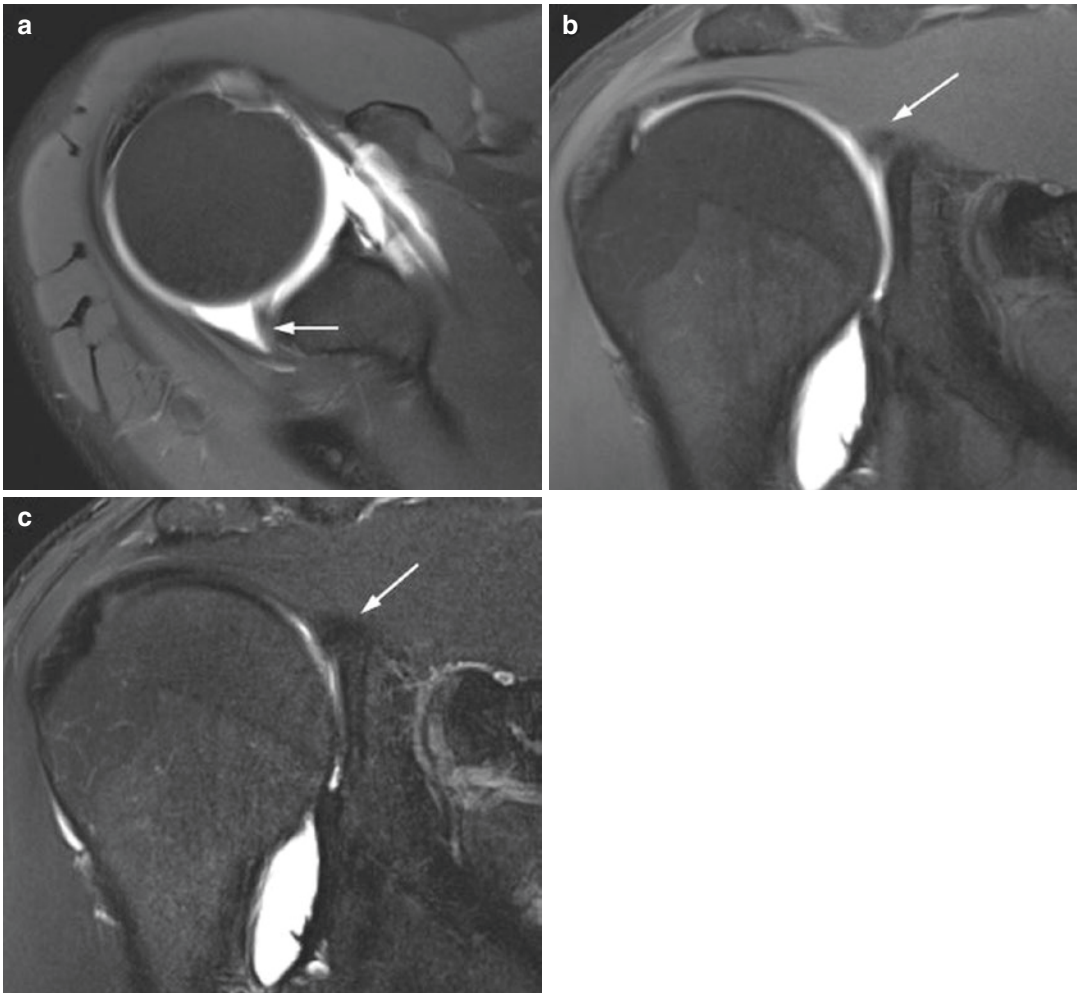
Magic angle phenomenon in the posterosuperior labrum. (a) Axial and (b) coronal fat-suppressed T1-weighted MR arthrographic images demonstrate intermediate signal in the posterosuperior labrum (arrow). (c) Coronal T2-weighted image, which has a longer TE (echo
